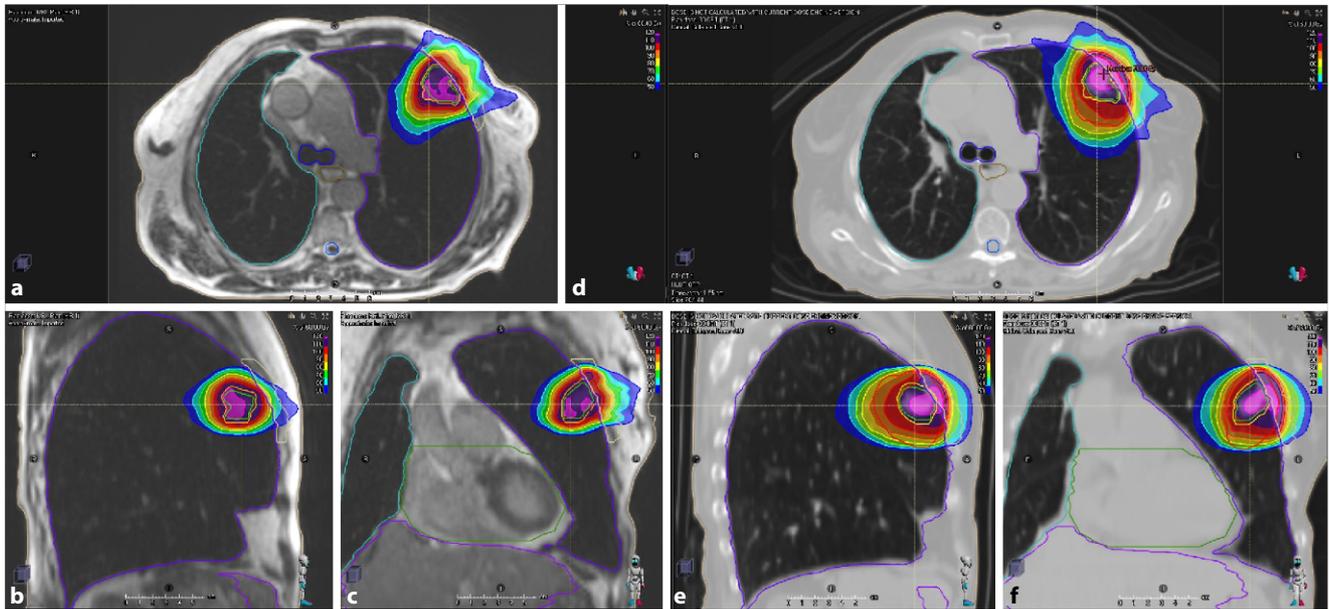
▲ Treatment plan for patient 1 (lung metastasis) as applied at the magnetic resonance(MR)-Linac using gated treatment in breath-hold shown as axial, sagittal and coronal images (a–c). Retrospectively generated computed tomography (CT)-based plan with internal target volume (ITV) in axial, sagittal and coronal images showing a larger treatment volume compared with the MR-Linac plan (d–f)
